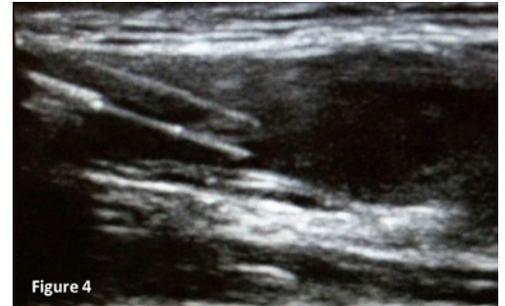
Ultrasound image with the transducer turned for an in-plane technique. The catheter can be observed as it is threaded off the needle into the vessel.
